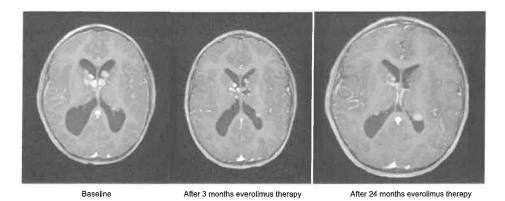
Asymptomatic adolescent male with bilateral SEGAs and obstructive hydrocephalus identified on screening MRI, judged to be unresectable, and response after 3 months and 24 months of everolimus therapy. Contrast-enhanced MRI. Gross total resection of bilateral giant cell astrocytomas is typically difficult and more prone to complications. Patient continues on everolimus with a total treatment duration of more than 10 years.
